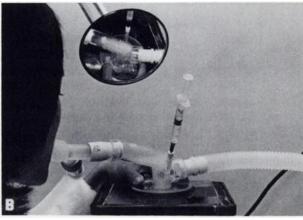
(A) Side view of nebulization chamber, showing position of impaction sphere. Aerosol is trapped below sphere until patient inhales. (B) Nebulization chamber atop ultrasonic unit, with shielding removed. Injection inlet permits gradual addition of ⁶⁰TC-phytate during delivery. Concentrated aerosol bolus and impaction sphere can be seen in mirror view of chamber.
